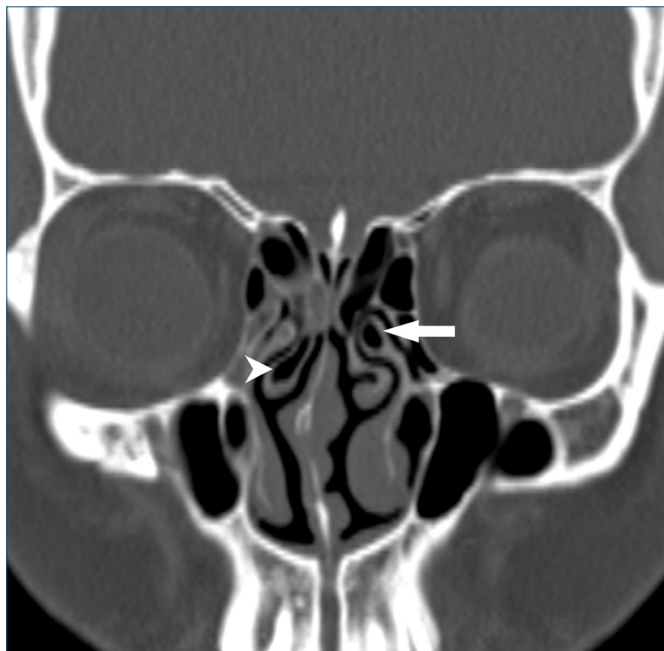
On coronal section CT, showing right middle turbinate bullosa (arrowhead) and left uncinate process pneumatization (white arrow)
